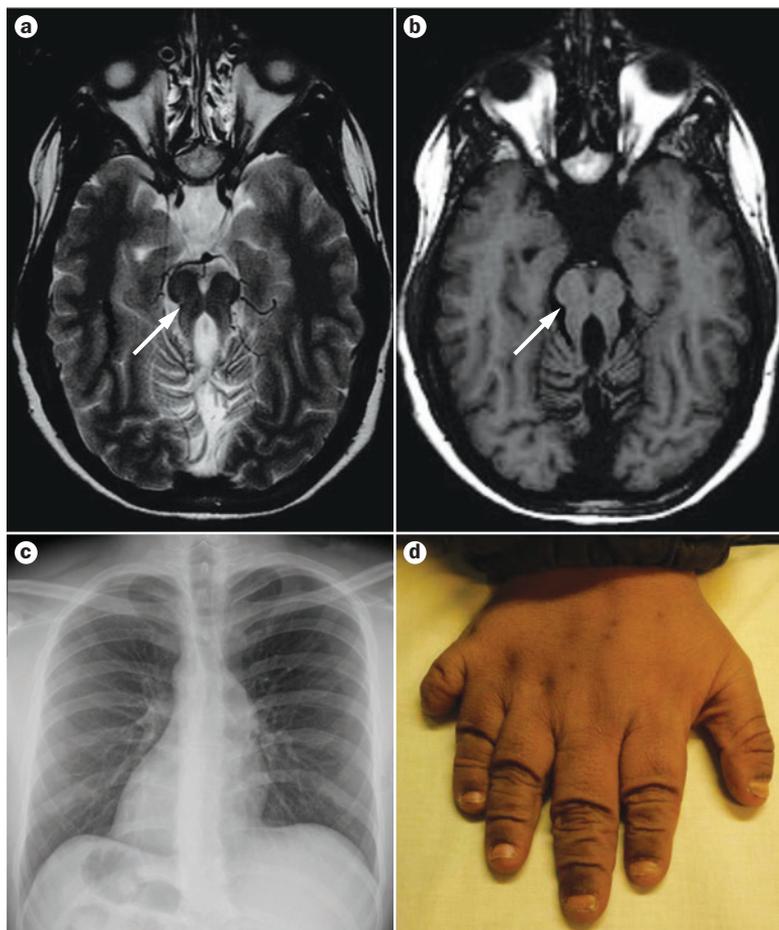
Extrarenal manifestations of rare cystic kidney diseases. a | T2-weighted and b | T1-weighted brain MRI scans from a patient with Joubert syndrome, showing cerebellar vermis aplasia and a malformed brain stem (molar tooth sign, white arrows). c | X-ray image showing *situs inversus* in an adult patient with nephronophthisis and Senior-Løken syndrome. d | Hexadactyly in an adult patient with Bardet-Biedl syndrome.
